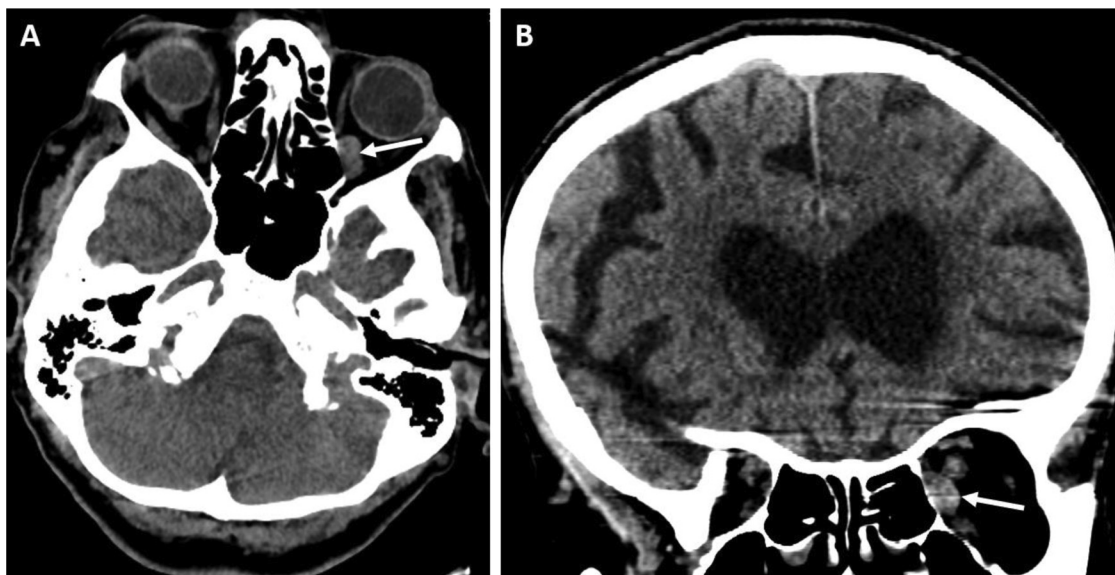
CT examination, axial image (A) and coronal reconstruction (B): a mass within the left orbit was reported as an incidental finding on CT (arrow).
